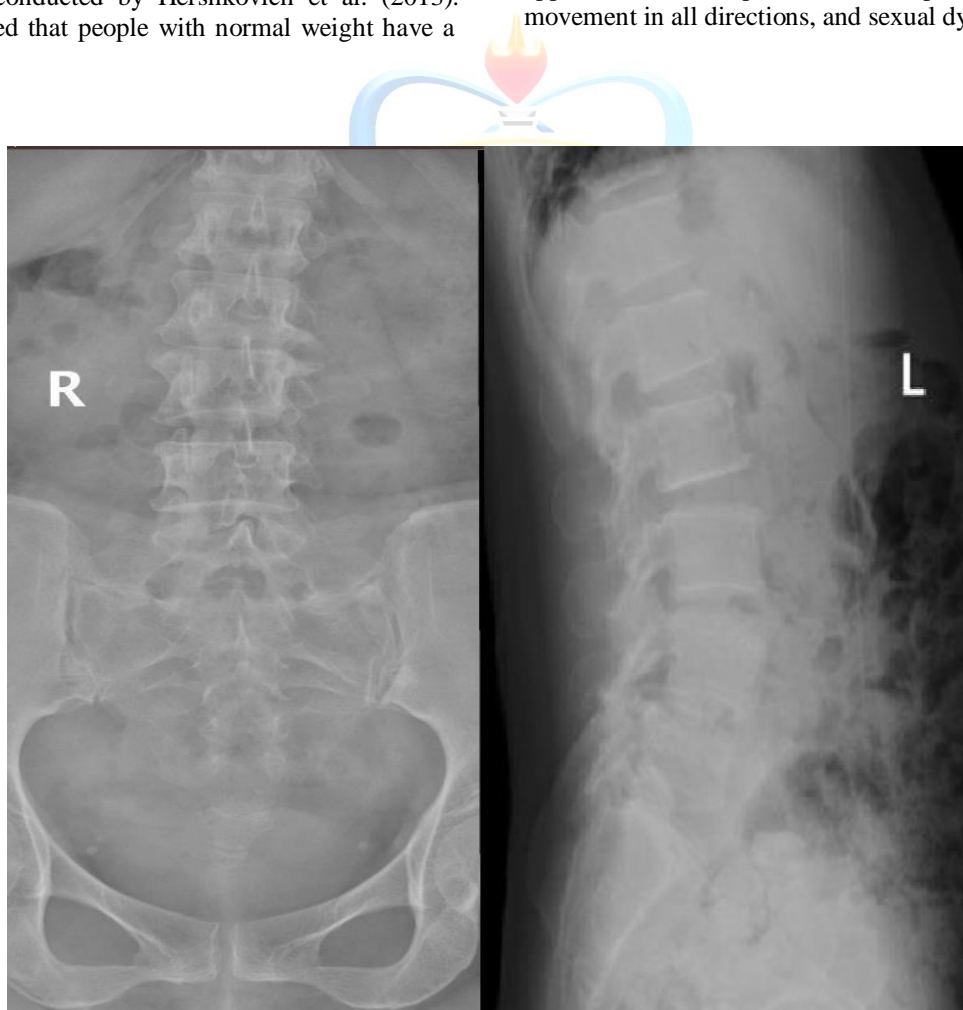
A 55-year-old female patient with LBP has experienced spondylosis, spondylolisthesis, unstable lumbosacral, and a paralumbar muscle spasm on a plain lumbosacral X-ray.
